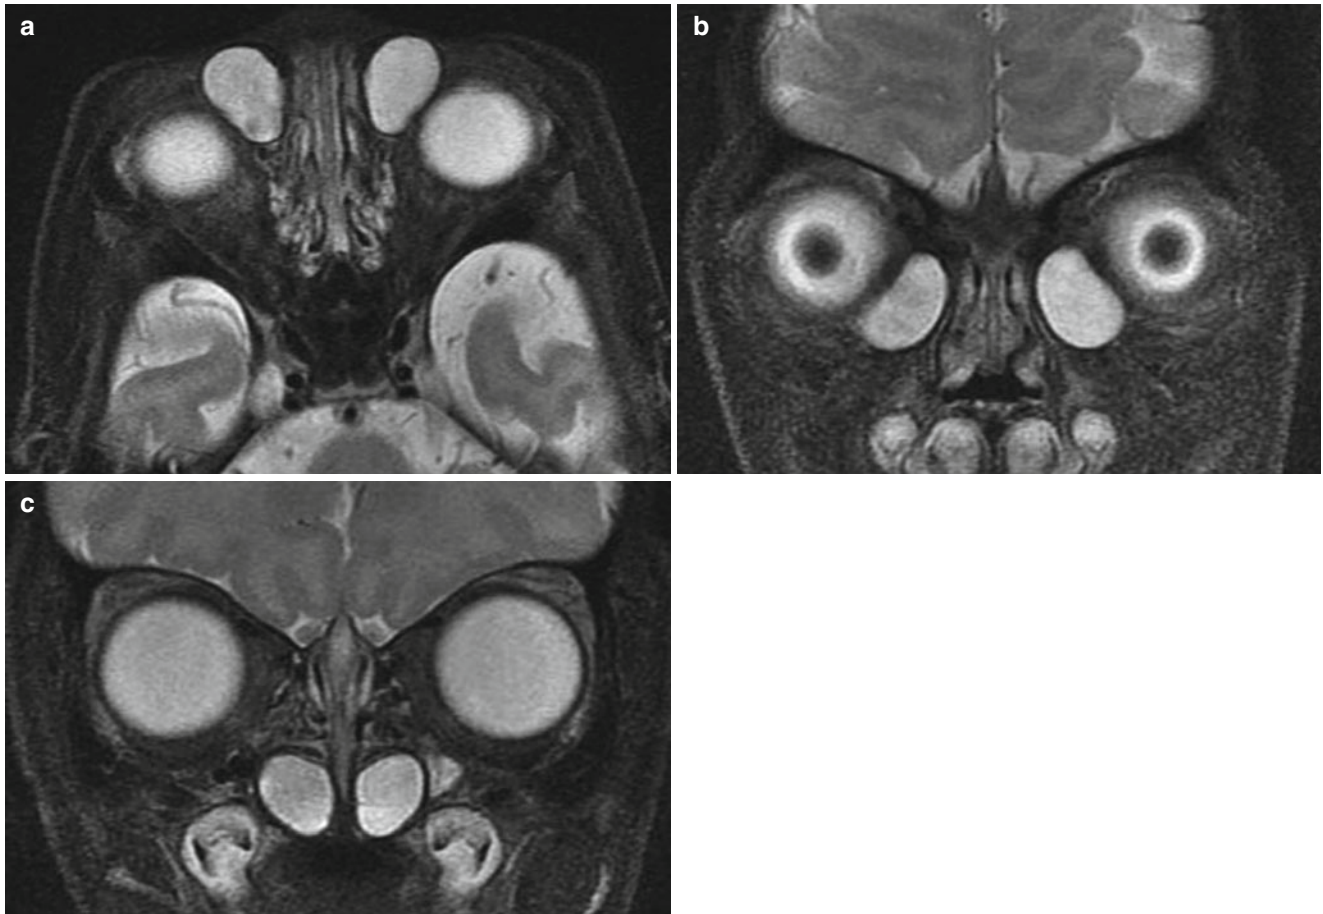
Nasolacrimal duct cysts in a 15-day-old girl. (a) Axial T2-weighted image shows cystic masses in the medial canthus of both the orbits. (b, c) Coronal T2-weighted images show the cystic masses extending from the medial canthus into the nasal cavities along the nasolacrimal ducts
